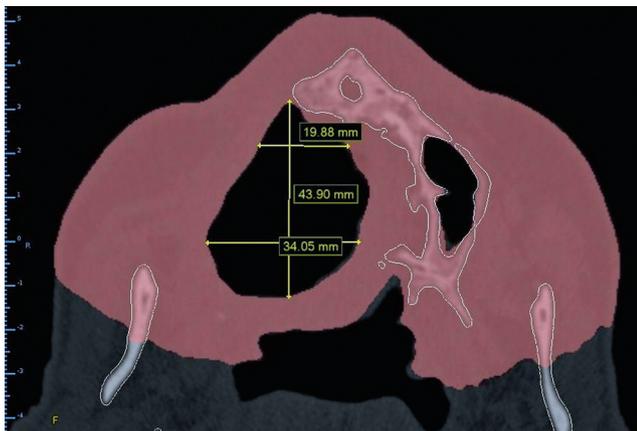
Postoperative computed tomography scan. Coronal view.
